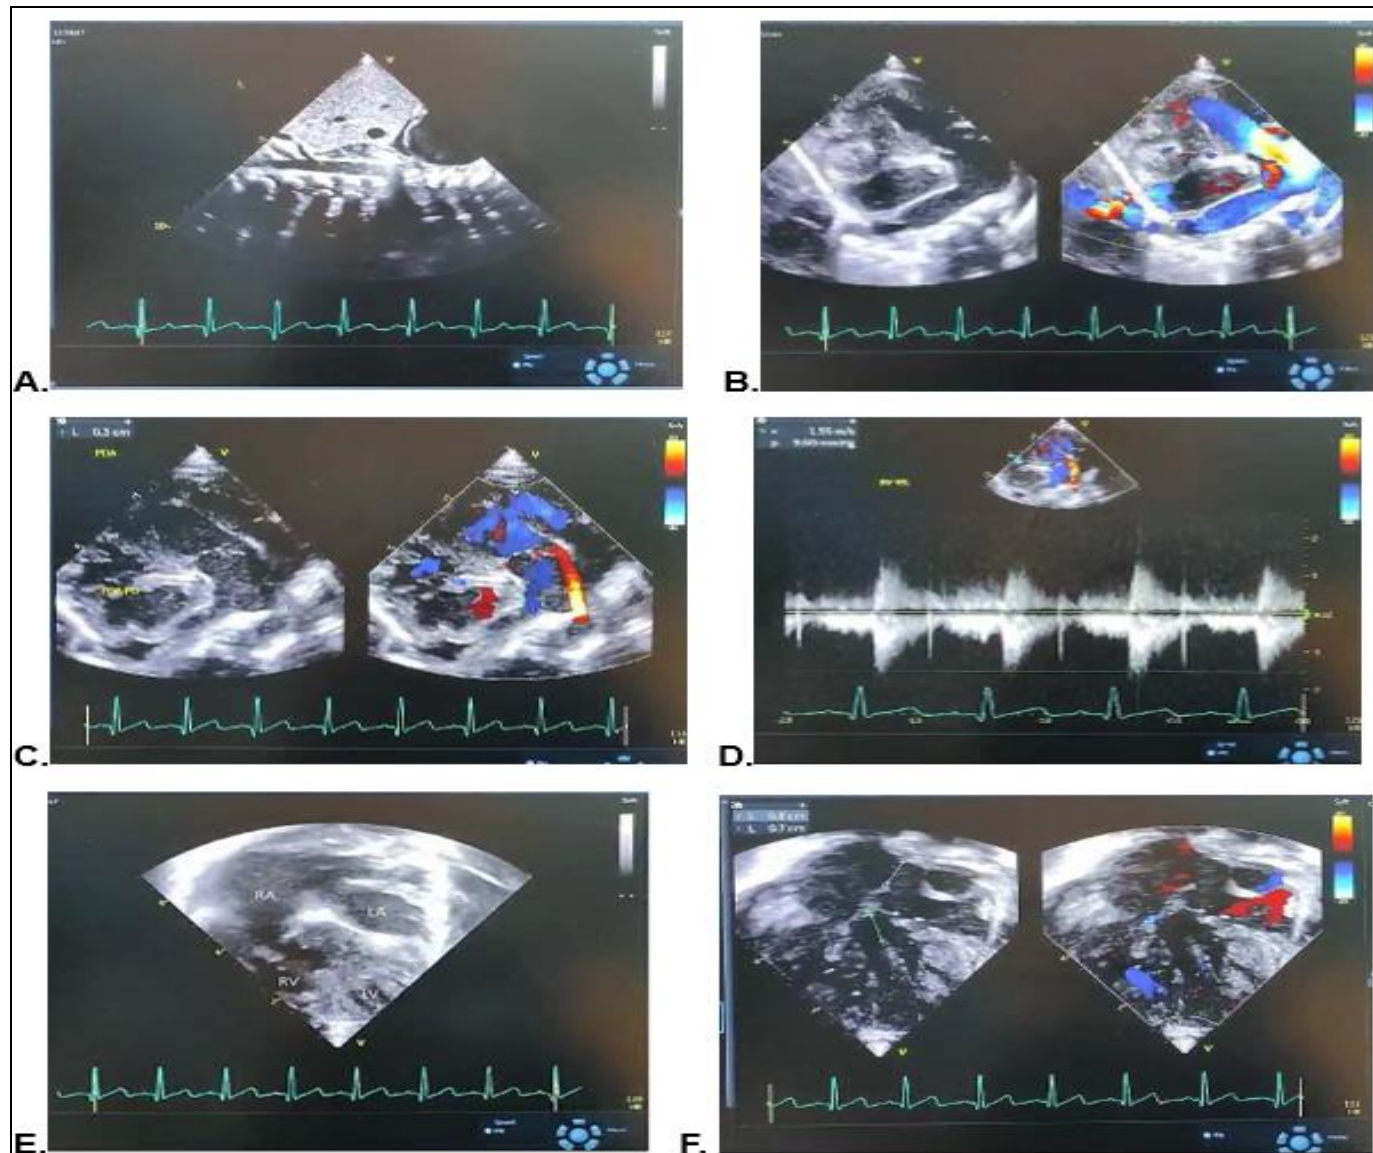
(A) Subcostal View Showed Situs Ambiguus with both Interrupted IVC and Aorta were not Pooled to RA, Suggesting LA Isomerism (B) Parasternal Long Axis (PLAX) View Showed Non-Restrictive VSD and great artery overrides ventricular septum by more than 50%, the great artery has an immediate posterior sweep, suggesting that its is PA, note the separation of anterior mitral leaflet and pulmonary valve (C) Parasternal short axis (PSAX) View Showed Two Great Arteries (Aorta and PA) Were Side by Side, Ao was at the Right Side of PA, PDA was seen with Size 3 mm, L to R shunt, (D) Color Wave Doppler of PA Showed RV-PA Gradient 9.6 mmHg Indicating Absence of PS (E) Apical Four Chambers (A4C) View at Diastolic Phase Showed Hypoplastic LV and Mitral Atresia, (E) Measurement of VSD Muscular Inlet Type Size 8 mm and ASD SVD Type Size 7 mm.
